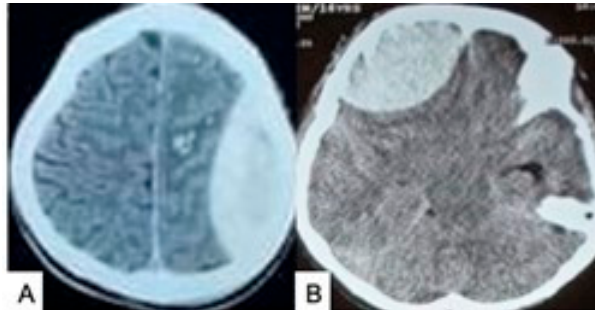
CT scan showing a typical extradural hematoma: (A) parietal convexity EDH; (B) frontal EDH. Source: Figure by authors.
